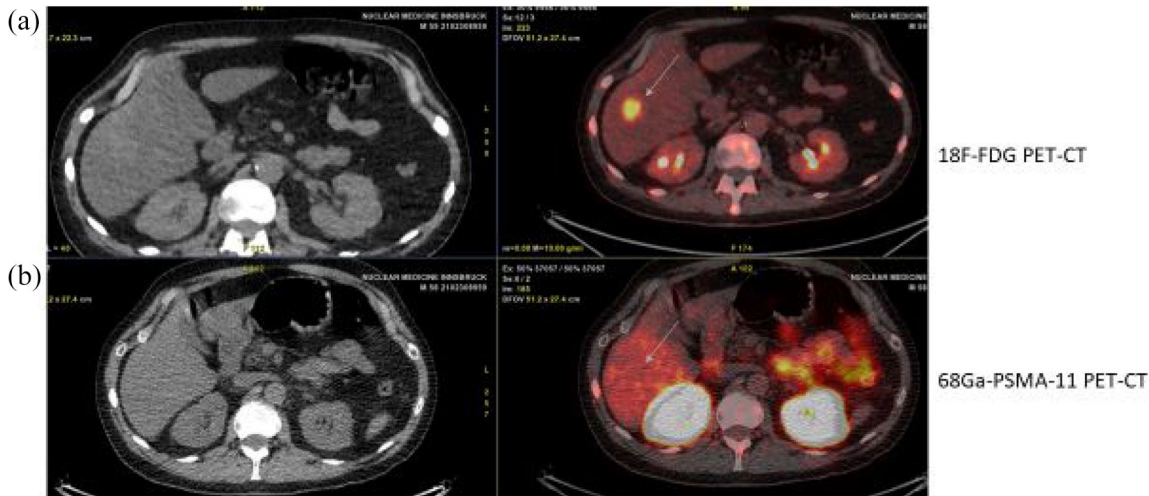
18 F-FDG PET-CT (a) and 68Ga-PSMA-11 PET-CT (b) images show an high uptake of FDG (SUV Max 9,25) in the liver metastasis with no relevant 68Ga-PSMA uptake.
